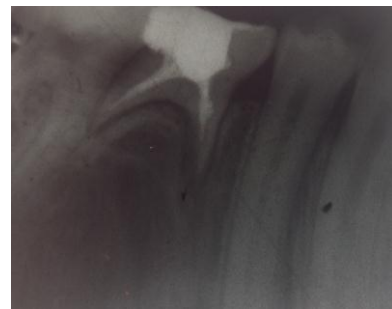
Immediate Post operative Intra oral Peri Apical Radiograph.
